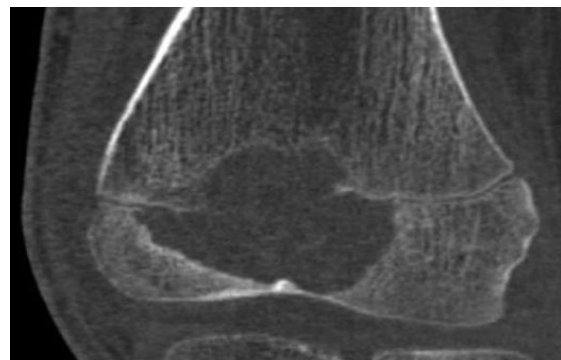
X-Ray femur showing an area of translucency with calcification.
